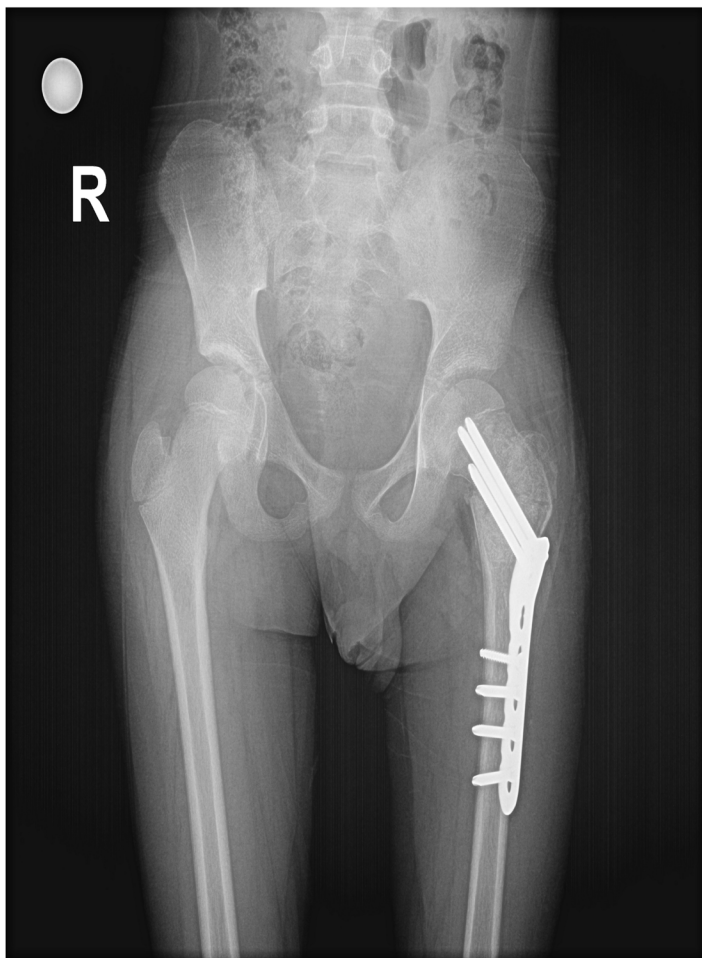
Early postoperative x-ray shows open reduction + curettage + allograft packing + plate fixation
